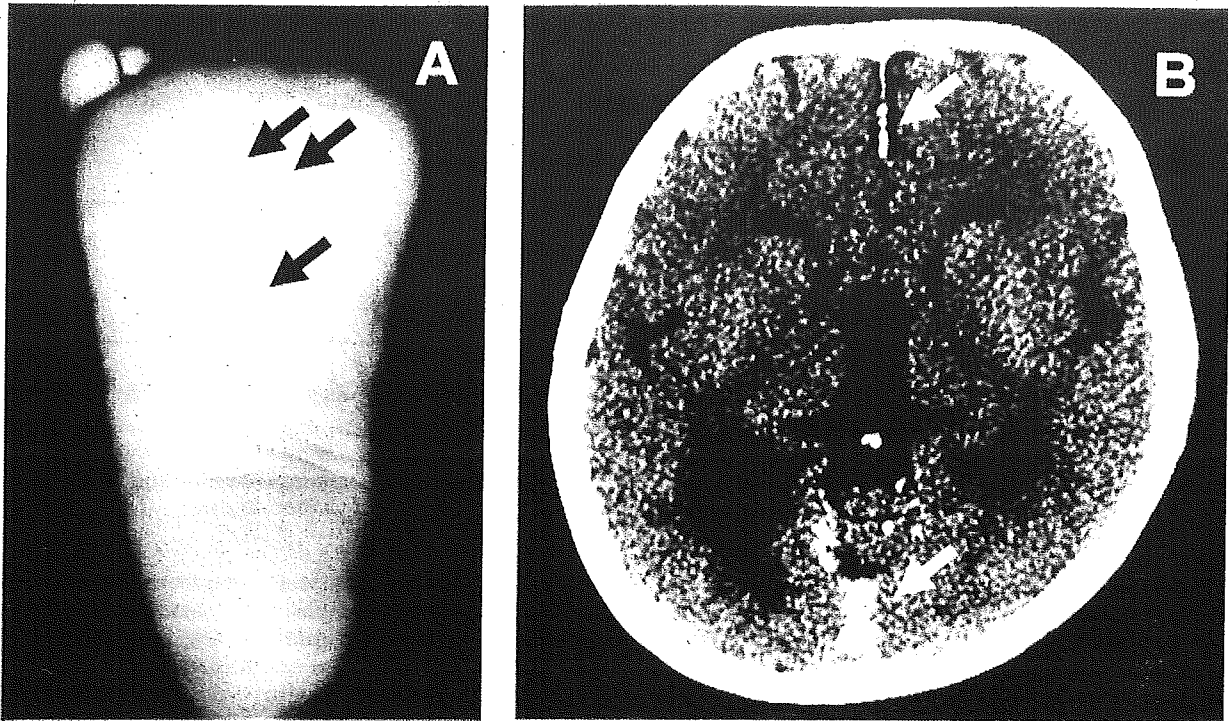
A: Plantar pits (arrow). B: Brain CT revealing calcification of the falx cerebri (arrow).
